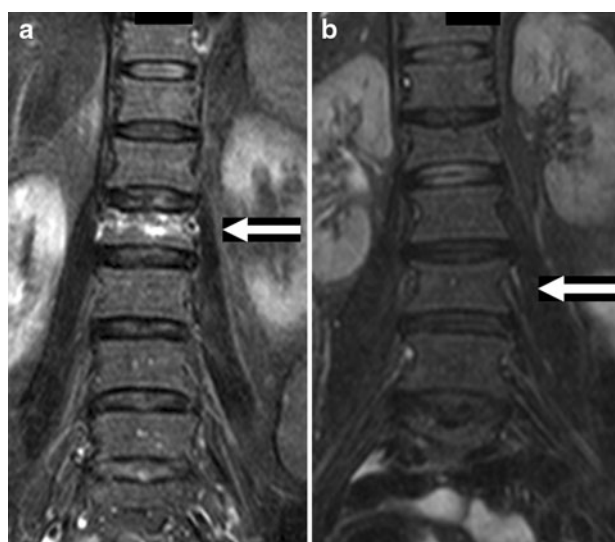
MR images of painful osteoporotic vertebral fractures with (a) and without (b) bone marrow edema. The presence of bone marrow edema was defined as an increased signal intensity on fat-suppressed T2-weighted turbo inversion recovery magnitude sequences (TIRM) of the vertebral fractures (Siemens Avanto, 1.5 tesla)
